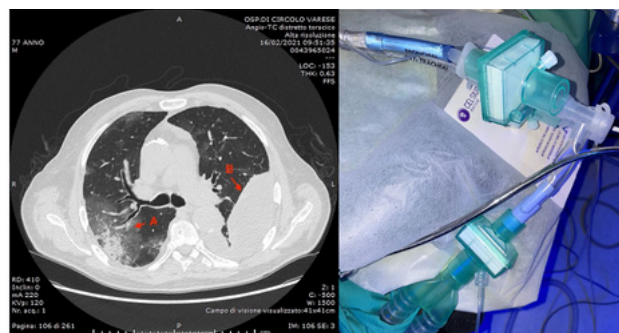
On the left, chest CT image:
